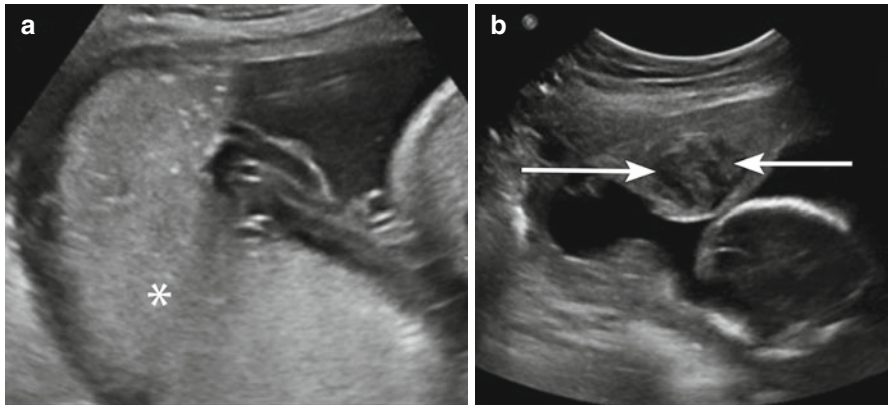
(a) Transverse image from a pelvic ultrasound (US) shows a normal-appearing placenta (*asterisk*). (b) In a different patient, the US shows a focal hemorrhage (*arrows*) within the placenta due to focal abruption
